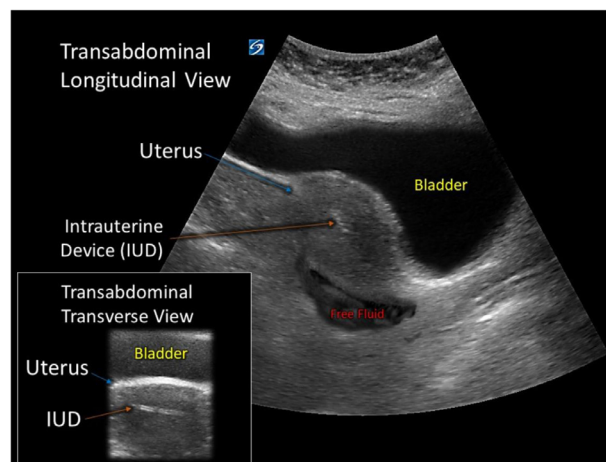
This is a transabdominal longitudinal view and a transabdominal transverse view using ultrasound. This shows the uterus and bladder with free fluid in the pelvis. The IUD is also shown.
